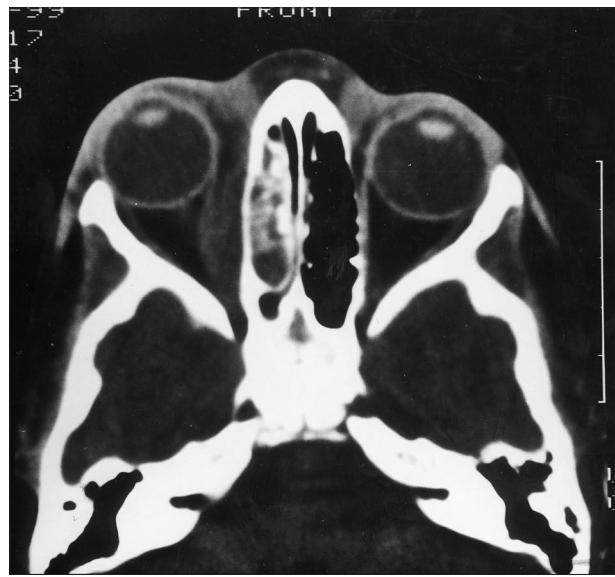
Axial computed tomography scan showing opacity of most of the anterior and posterior ethmoids. Soft tissue swelling displacing medial rectus and proptosis of the right eye.
